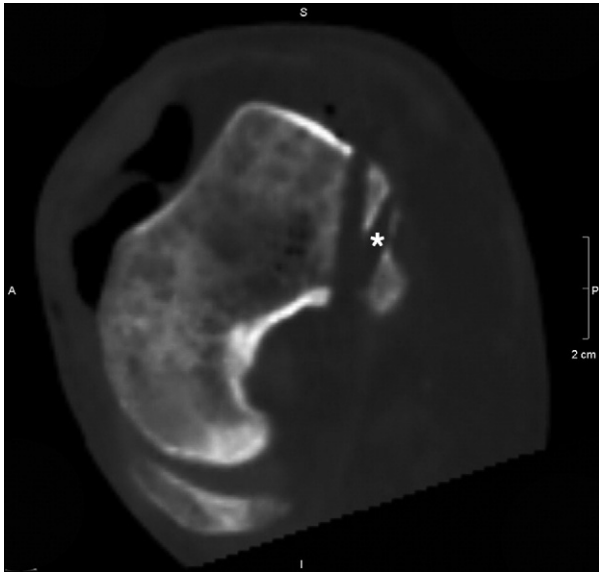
CT scan image, coplanar with both tunnels. The posterior tunnel (asterisk), which was drilled with the help of the offset aimer at 110° of knee flexion, measured only 23 mm in length.
